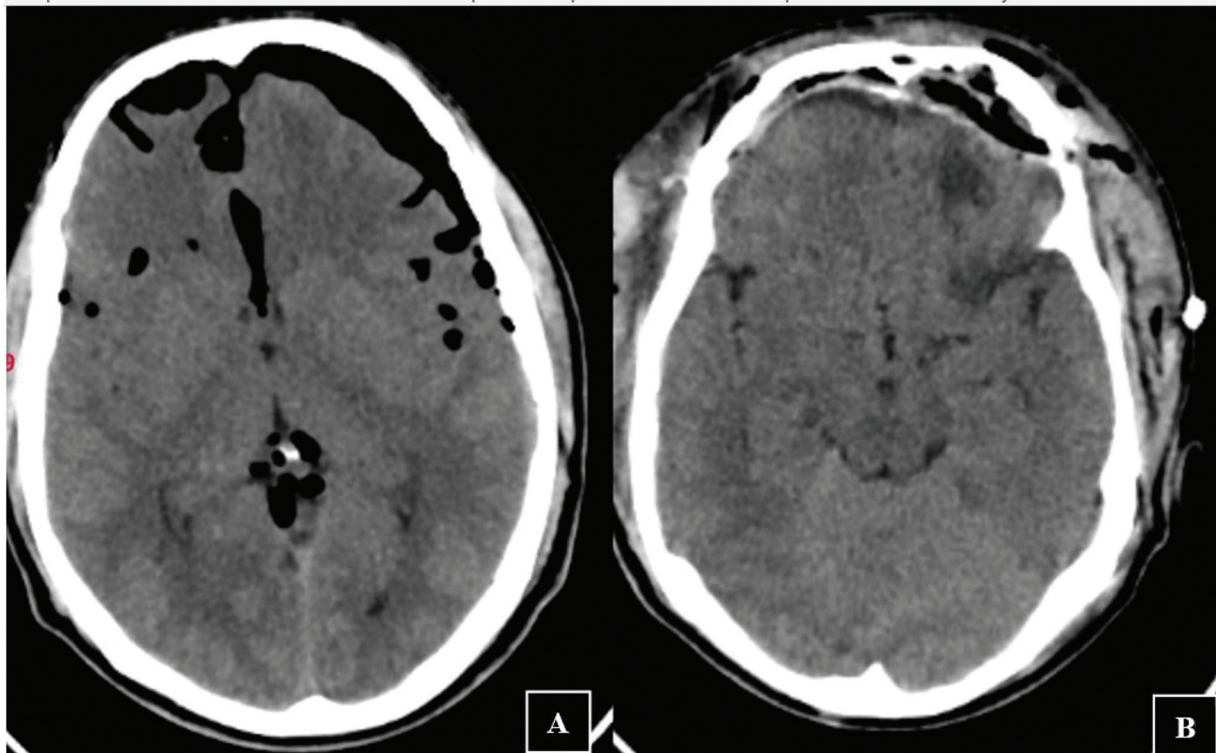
(A) Preoperative and (B) postoperative computed tomographic images of the brain.
